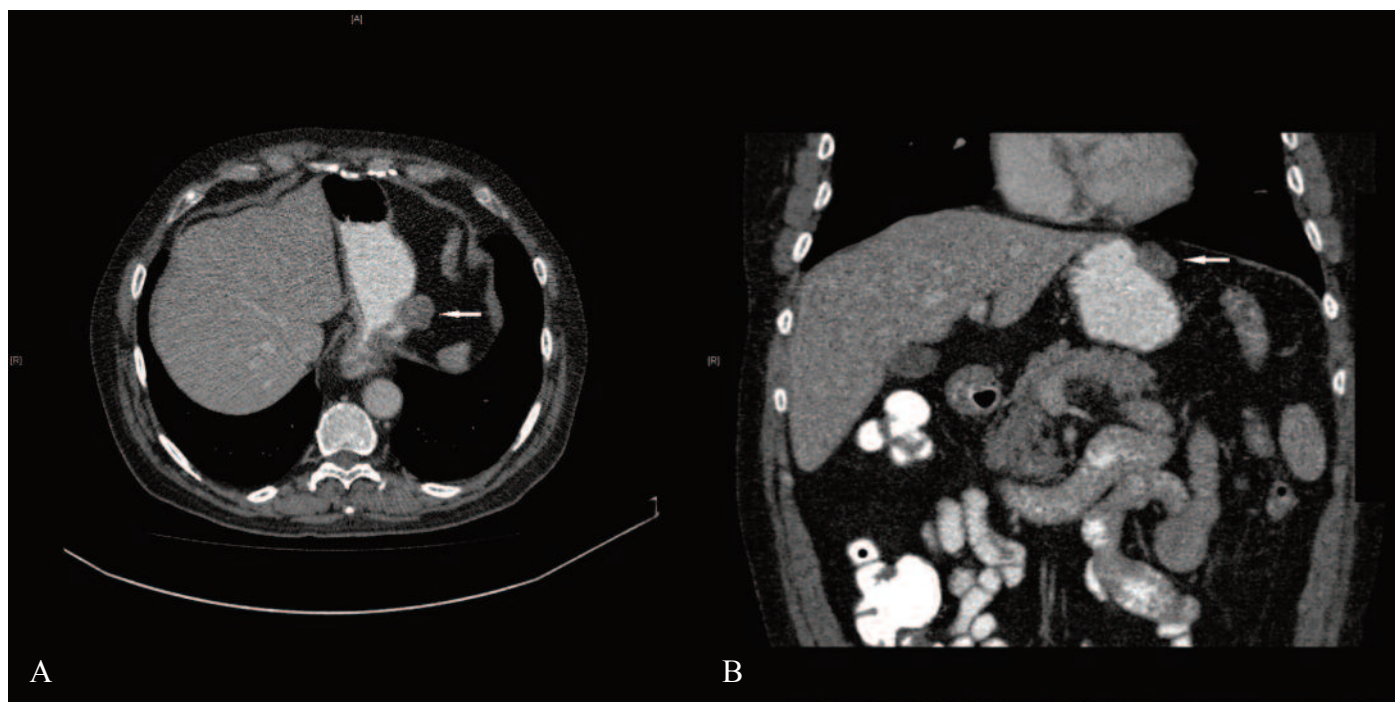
Axial (a) and coronal reformat (b) contrast enhanced CT images showing an exophytic, non-enhanced, mass (arrow) located at great curvature of stomach.
